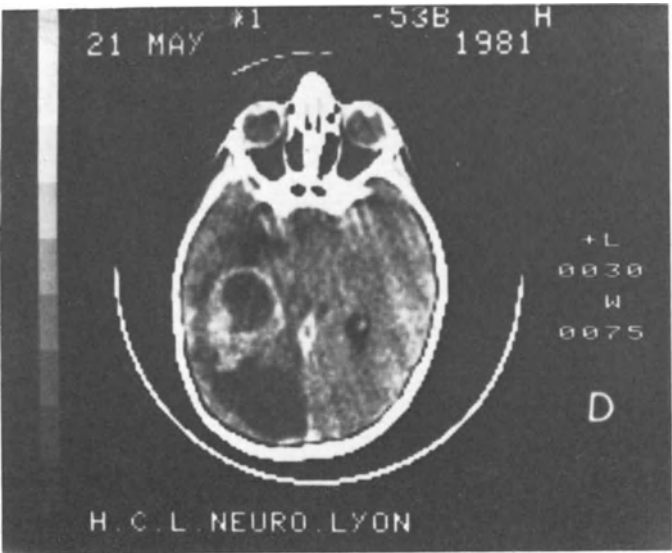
Enhanced CT appearance of a grade II ependymoma with a cyst-like trapped occipital horn
